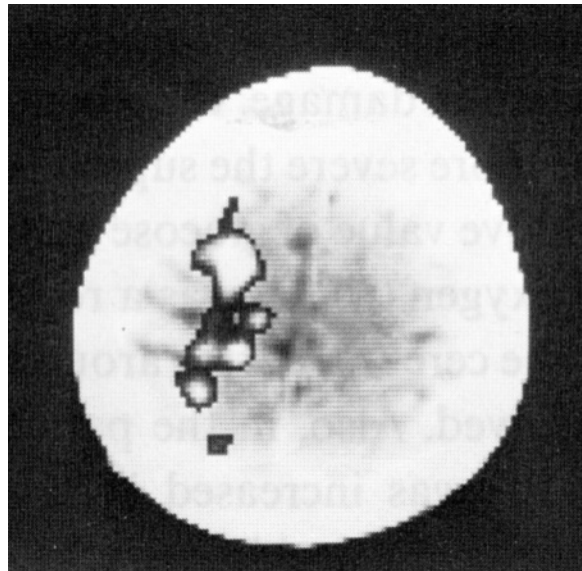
Superposition of PET and CT scans of CPSP patients showing increased activity in SI/MI (from Hirato *et al.* 1993).
